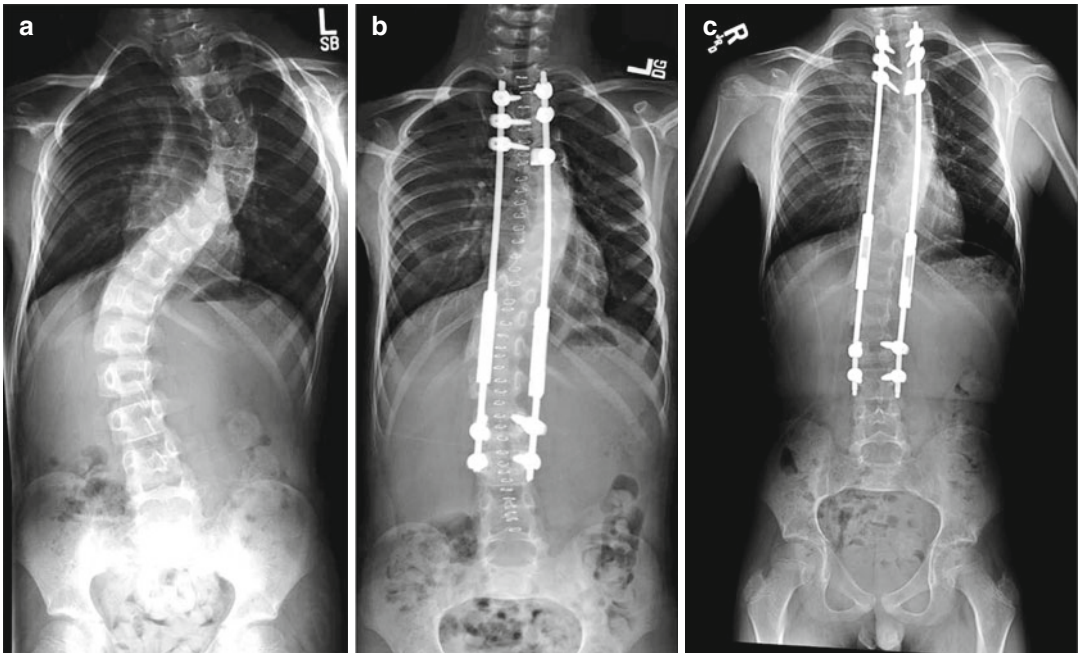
(a–c) Pre- and postoperative radiographs of patient treated with “growing rod” construct for juvenile scoliosis. The boxlike structures in the lower part of the construct are lengthening boxes. The third image
